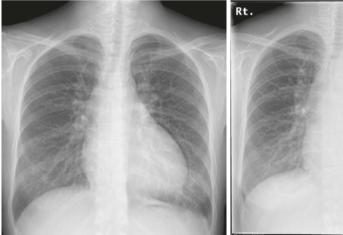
Chest X-ray before and during pregnancy
